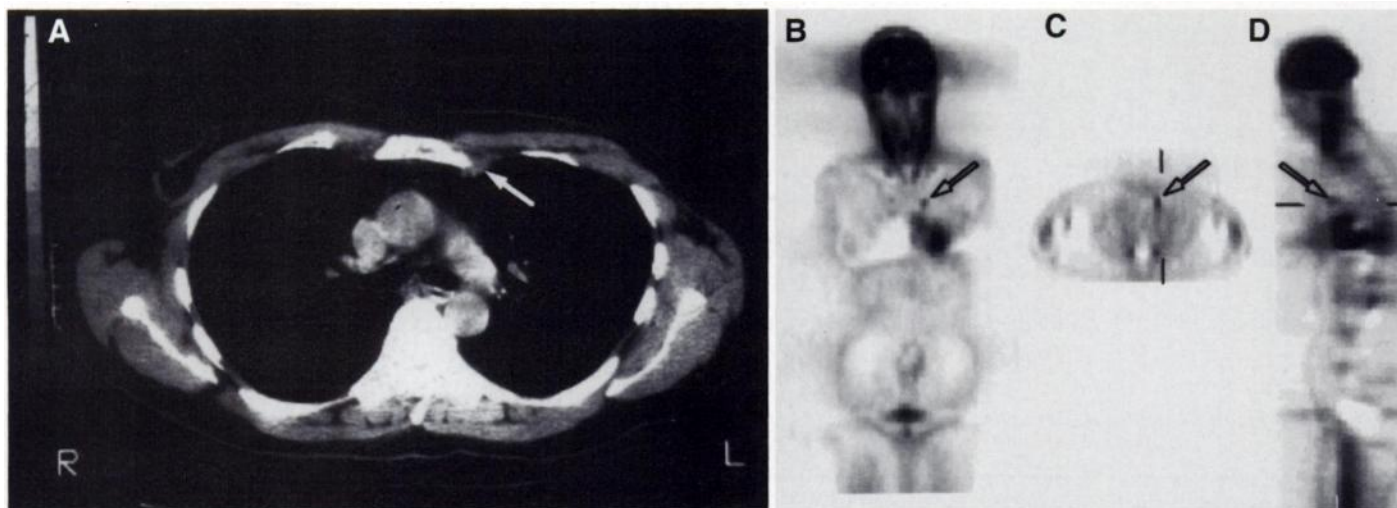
A 43-yr-old woman with breast cancer. (A) Chest CT scan shows 1-cm-sized left internal mammary lymph node enlargement. PET scan was done to evaluate the significance of the lesion and the presence of other metastatic lesions. (B) Coronal, (C) transaxial and (D) sagittal FDG-PET images show focal uptake in the corresponding lesion. Fine-needle aspiration confirmed the metastatic carcinoma. Note the increased uptake of both sternocleidomastoid muscle and heart.
